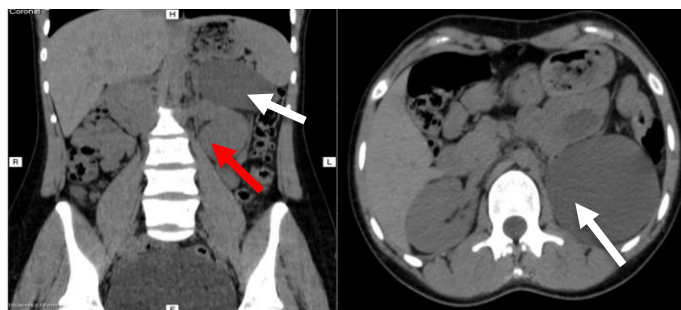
Abdominopelvic CT scan of the patient. A (left) shows coronal view of a huge left adrenal cyst (shown with white arrow). B (right) shows the axial view of the same lesion. The left displaced kidney is shown by the red arrow.
